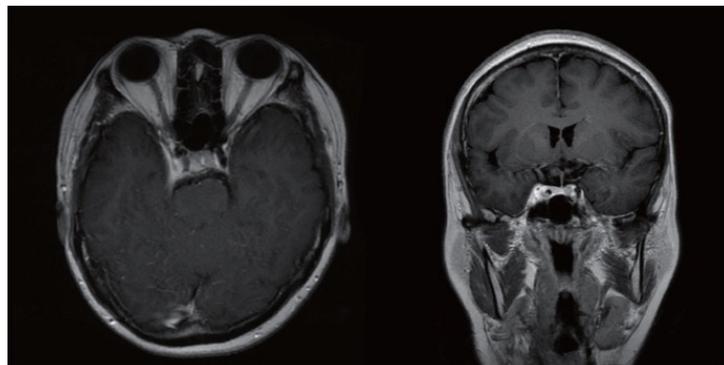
The latest follow-up MR images (in 2021) revealed reduced tumor and no progress
